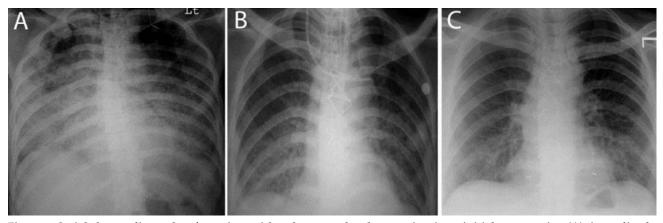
Serial chest radiographs of a patient with pulmonary alveolar proteinosis: at initial presentation (A); immediately after whole lung lavage (B); and at follow-up after two years (C).
